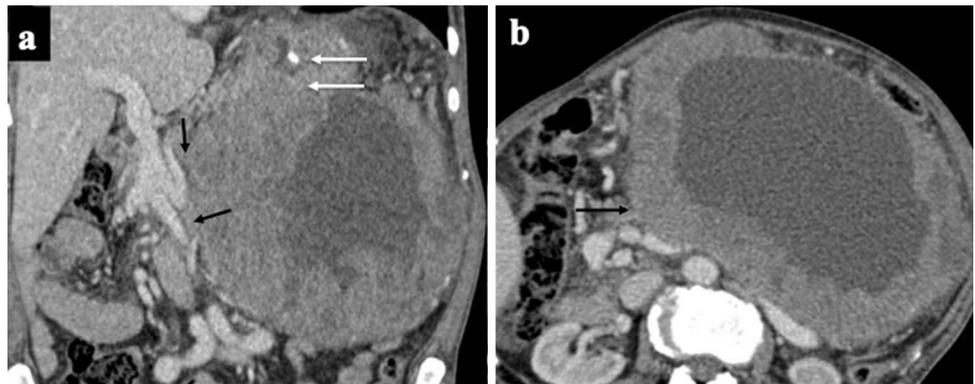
Gastro-intestinal stromal tumor (GIST) in a 70-year-old male. Coronal (a) and axial (b) contrast-enhanced CT images showing a heterogeneously enhancing mass arising from the greater curvature (white arrows) of the stomach and involving the mesenteric root (black arrows)
